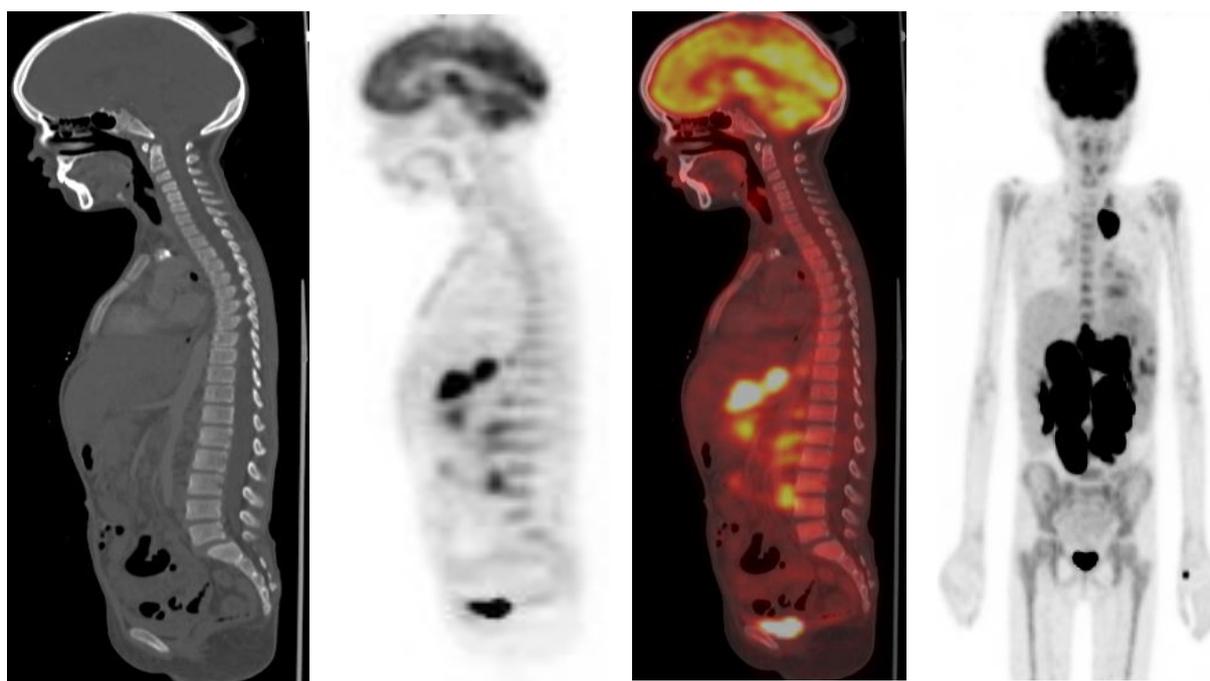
PET CT of known case of HD with diffuse FDG bone marrow uptake likely due to hyperplasia.
